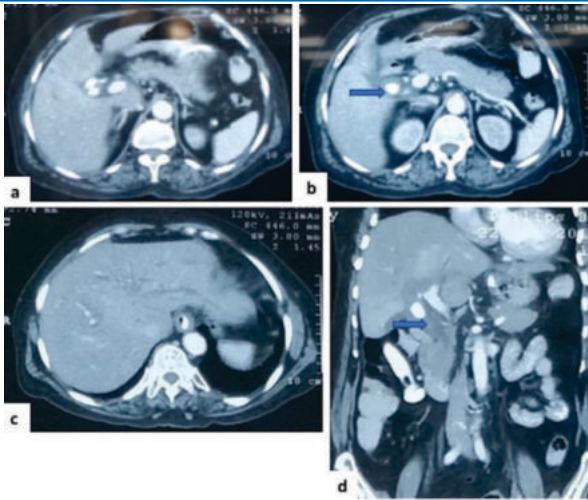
CT abdomen images showing pseudoaneurysm arising from right hepatic artery (arrow in b) causing compression over upper CBD (arrow in d). Bilobar intrahepatic biliary radicles dilatation is seen (c)
